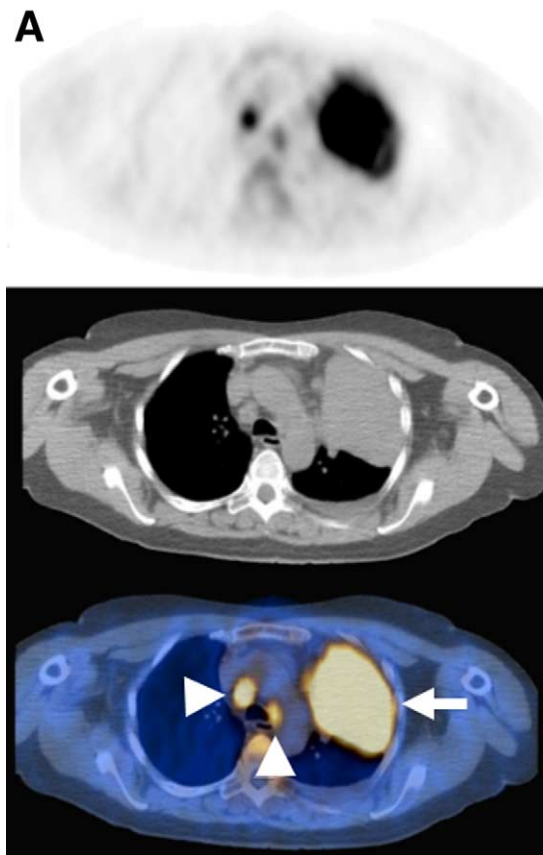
FDG-PET and osseous metastases. A 67-year-old subject with a large left upper lobe NSCLC. (A) Axial PET/CT fusion images showing the large hypermetabolic cancer in the left upper lobe (arrow) with metastatic disease to pretracheal and left paratracheal lymph nodes (arrowheads). (B) Selected axial PET/CT fusion images showing extensive osseous metastases, including rib (arrow), sacrum (arrowheads), and proximal femur (curved arrow). The inferior lesion in the sacrum (lower left image) was biopsied percutaneously, confirming the diagnosis of stage IV lung cancer.
